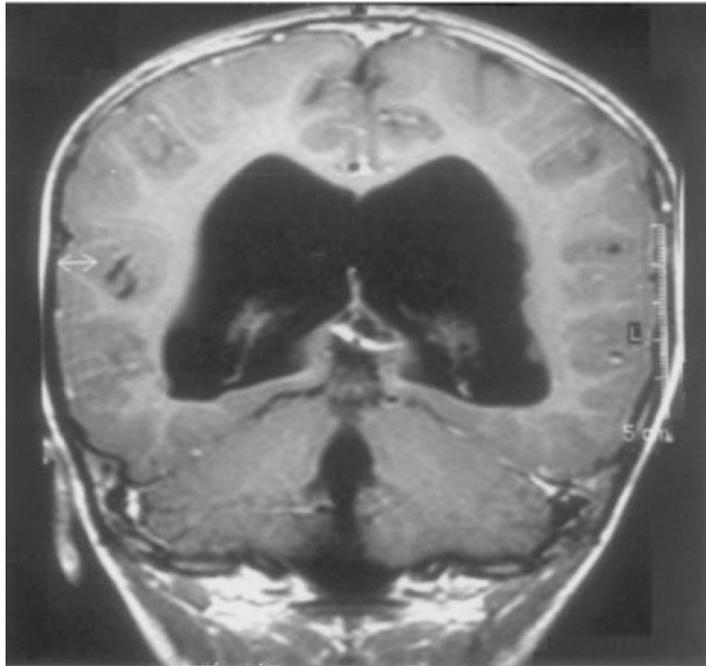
Patient 2. A: A three-dimensional CT scan reconstruction of the skull revealing a discontinuity at the midline of the occipital bone. B: T1-weighted MRI (coronal section) showing bilateral, subependymal, heterotopic nodules, more evident on the left side.
